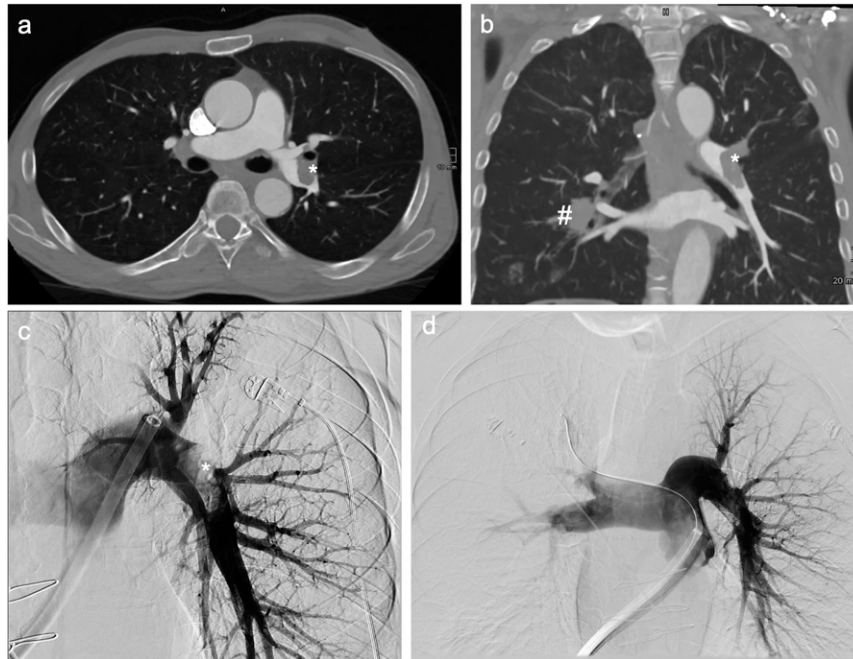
Mechanical aspiration of the left pulmonary artery (a), (b) Computed tomography angiography revealed pulmonary artery emboli in the left main pulmonary artery (*) and pulmonary metastasis (#). The smaller thrombus in the right segmental upper lobe artery is not shown. (c) Digital subtraction angiogram (DSA) before the intervention with a clear visualization of the embolus in the left main pulmonary artery (*). (d) DSA of the pulmonary arteries shows the near-complete embolus removal with only wall-adherent residual embolus remaining without any flow impairment.
